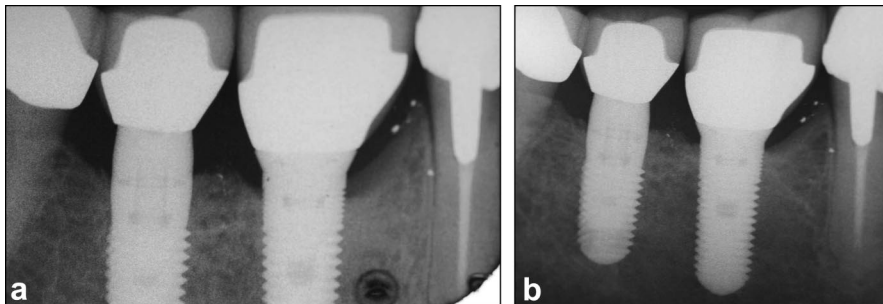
a, Radiograph of Screwplant at 24 months postrestoration of the implant. b, Radiograph of the same implant at 36 months. Minimal additional proximal bone changes have occurred.
